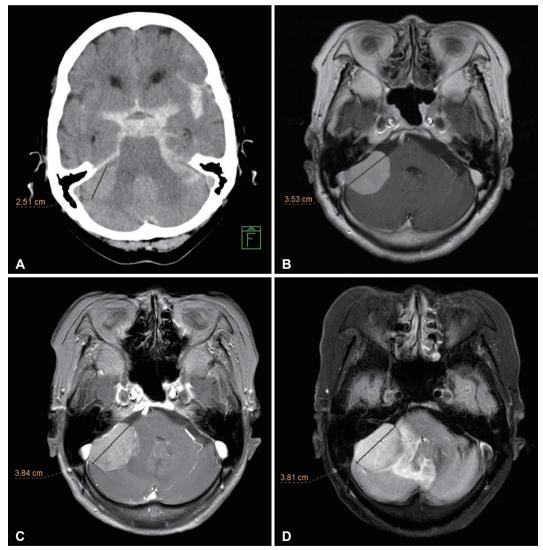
Initial CT angiography of a 74-year-old woman presented with decreased consciousness showing a 2.5-cm meningioma arising from the right cerebellopontine angle (A). During follow-up, 2 years and 6 months later, growth of the tumor to 3.5 cm (B). At 160 days after CyberKnife radiosurgery, the tumor size had increased to 3.8 cm (C) with symptomatic surrounding edema was observed (D).
